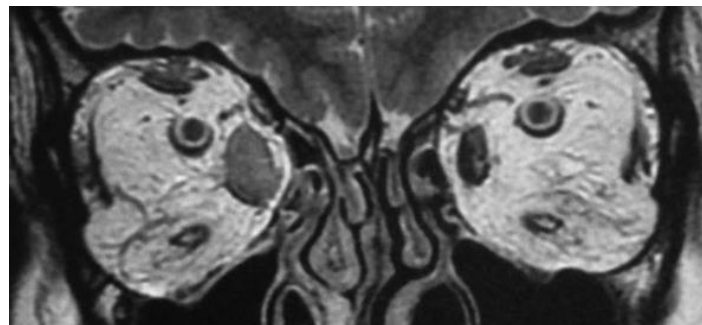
MRI: Both muscular and fat tissue augmentation in both orbits.
